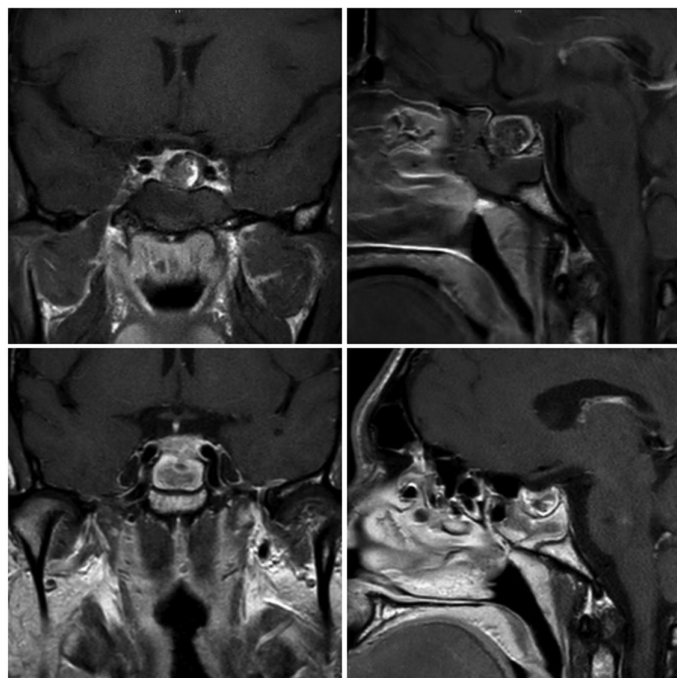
Pre-operative (top) and postoperative (bottom) MRI images.
